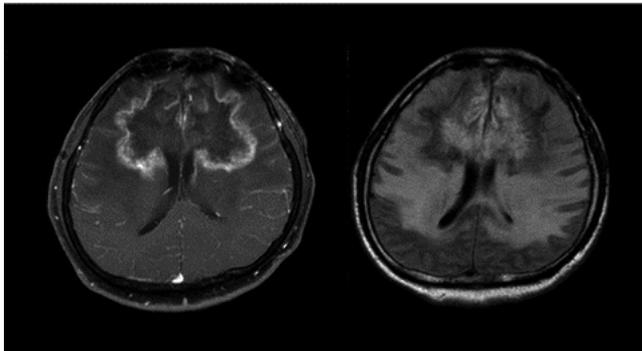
Gadolinium-DTPA enhanced T1 weighted image and FLAIR image
